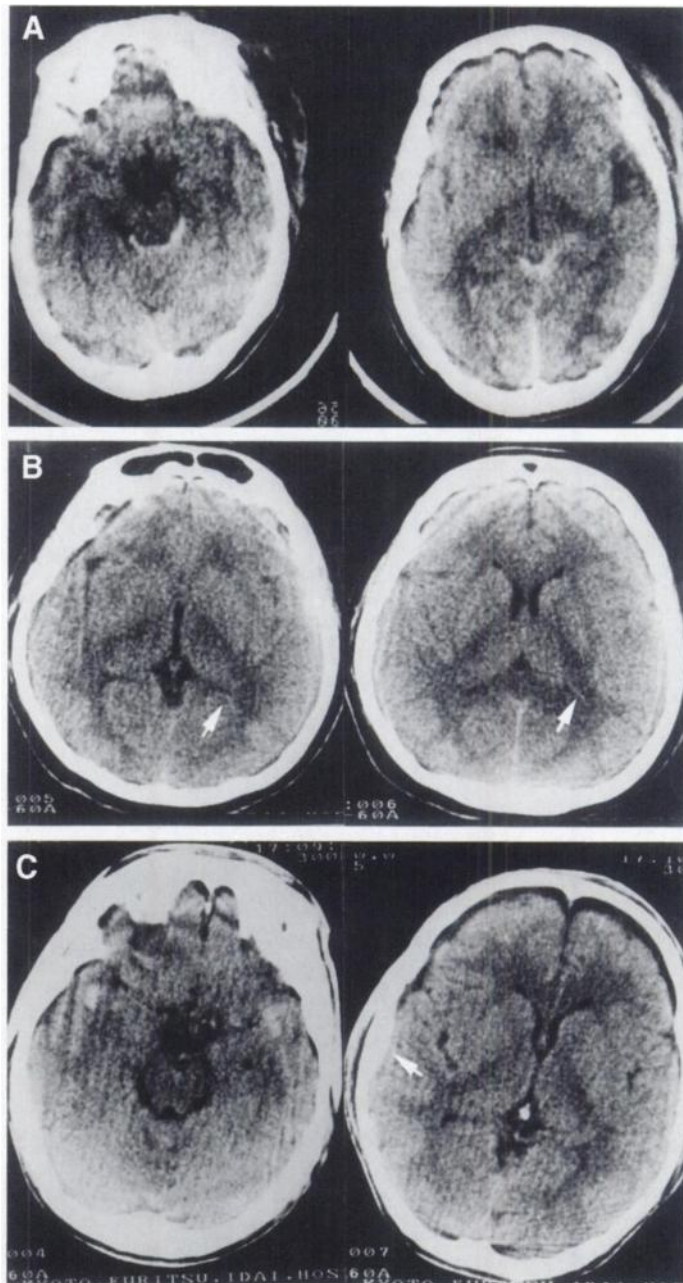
(A) Admission CT image of Patient 1 depicts traumatic subarachnoid hemorrhage in the ambient cistern, quadrigeminal cistern and cerebral contusion in the right temporal lobe. (B) Admission CT scan of Patient 2 demonstrates intraventricular hemorrhage in the left lateral ventricle (arrows). (C) Admission CT scan of Patient 3 shows small hemorrhagic lesions in the bi-temporal lobes and small epidural hematoma in the temporal region (arrow).
